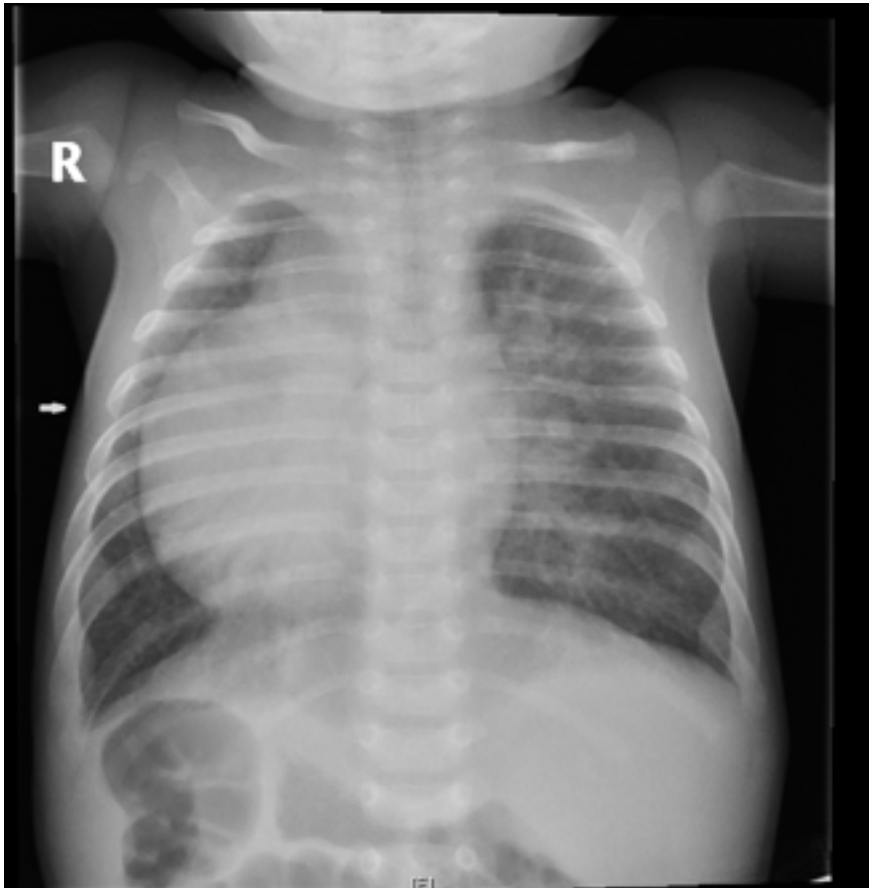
Chest X-ray showing dextrocardia.
